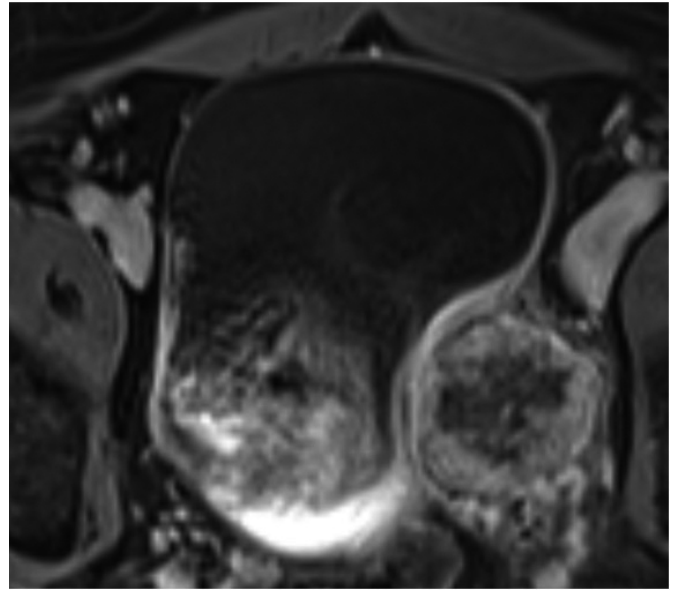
Axial contrast-enhanced, T1-weighted imaging shows a heterogeneous enhancing solid mass, with central hypoenhancement.
